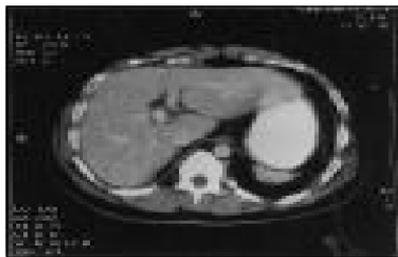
Computed tomogram of abdomen showing empty gall bladder fossa.
